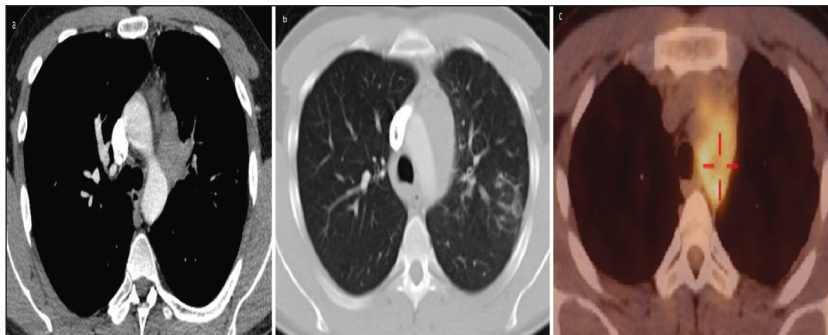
A) A hypodense mass lesion (approximately 8*6*3.5 cm in size) in the anterior mediastinum surrounded the vascular structures filling the aortopulmonary window and the hilar region is seen. B) There is an increase in reticulonodular density, starting from the left hilar area accompanied by peribronchial thickening along the bronchovascular interstitium, interlobular septal prominence, and ground glass density. C) The hypodense mass had an increased ^{18}F -fluorodeoxyglucose uptake with a standardized uptake value (SUV_{max}) of 6.5.
